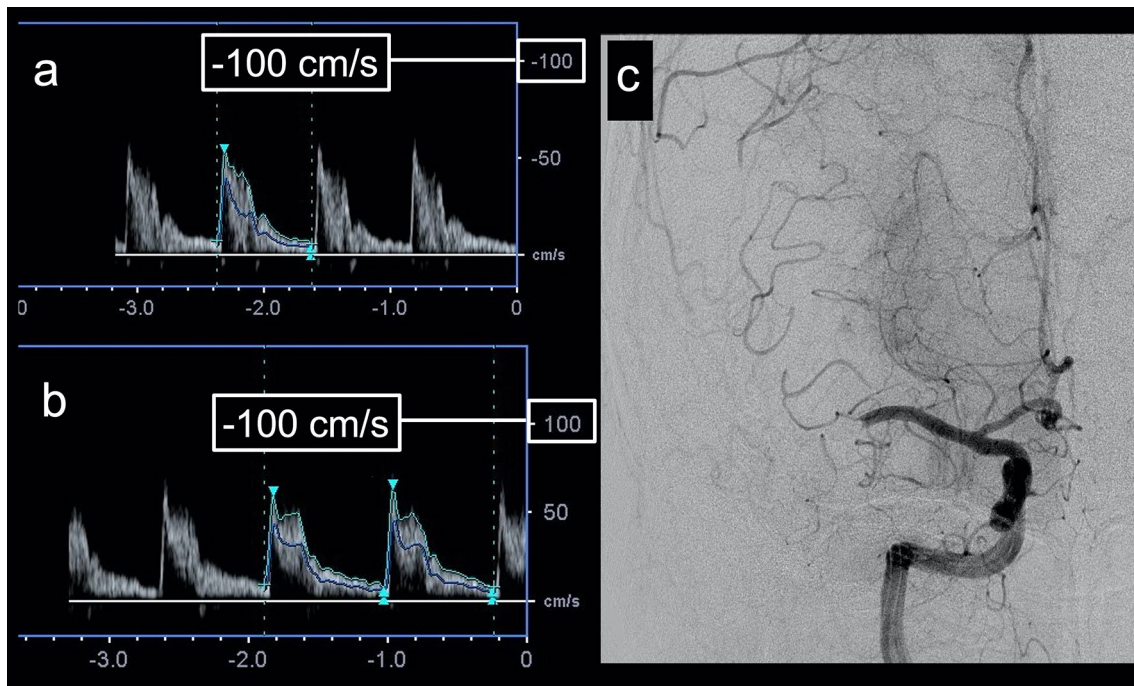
Ultrasound findings of MCA occlusion in cardioembolic cerebral infarction. PWD (a, b) and DSA (c) measurements are shown. The EDV values of the right (a) and left (b) CCA are 5.4 cm/s and 7.9 cm/s, respectively. Therefore, the ED ratio is 1.46. DSA (c)
